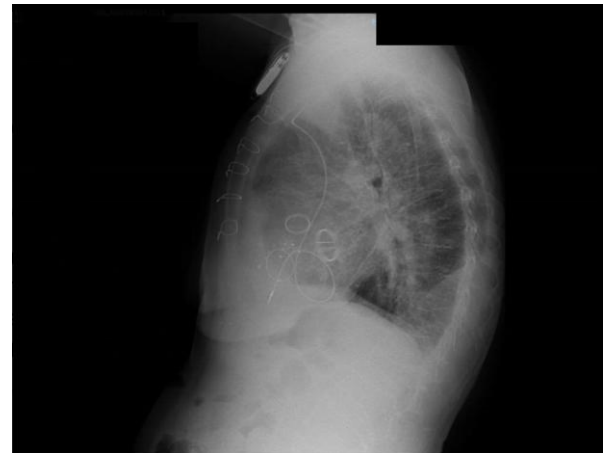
Lateral chest X-ray showing the three prostheses and the CardioMEMS device.
